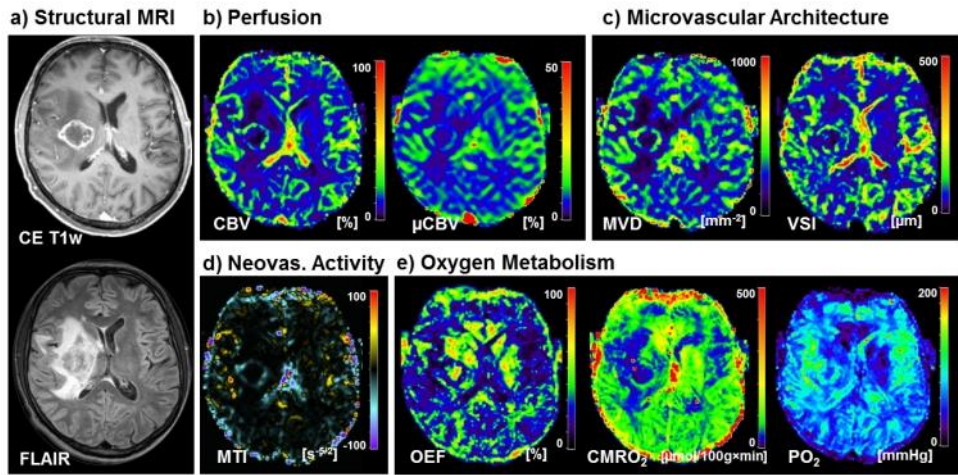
Physiological MR imaging of a patient diagnosed with a brain metastasis originating from bladder cancer.
